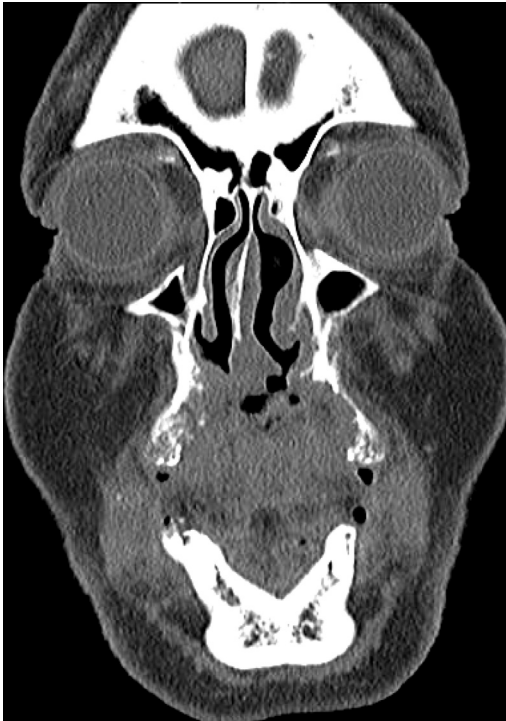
A 74-year-old man with mucoepidermoid carcinoma of a hard palate minor salivary gland. CT without contrast showing destructive lesion of the anterior maxilla.
